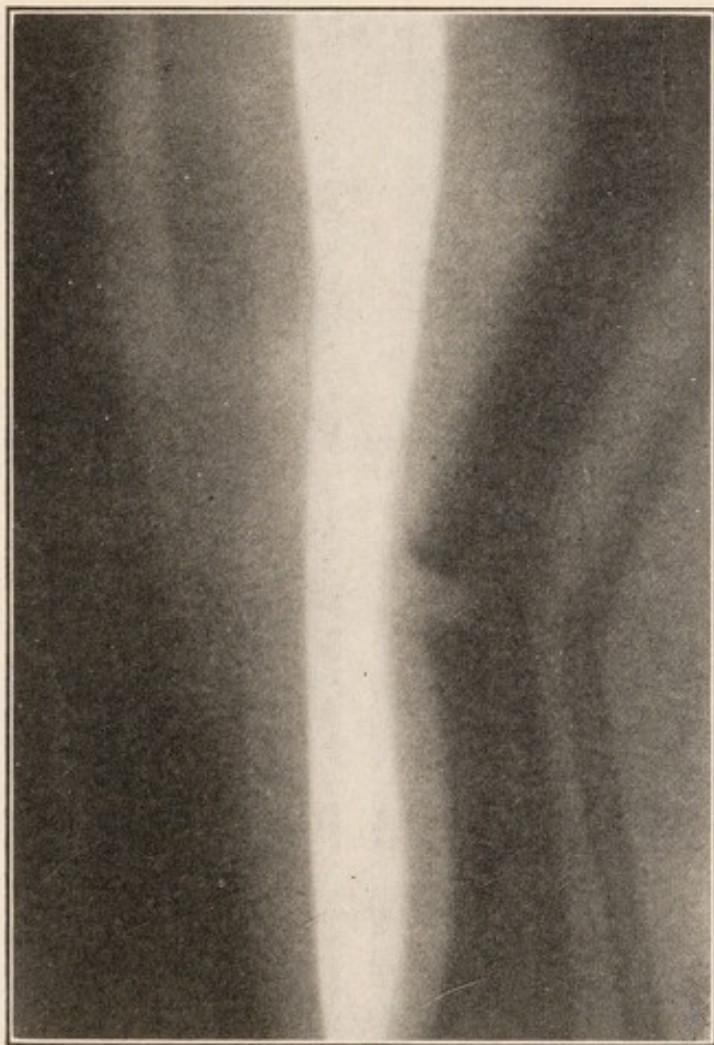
X-ray showing linear fracture of tibia after osteoclasis.
